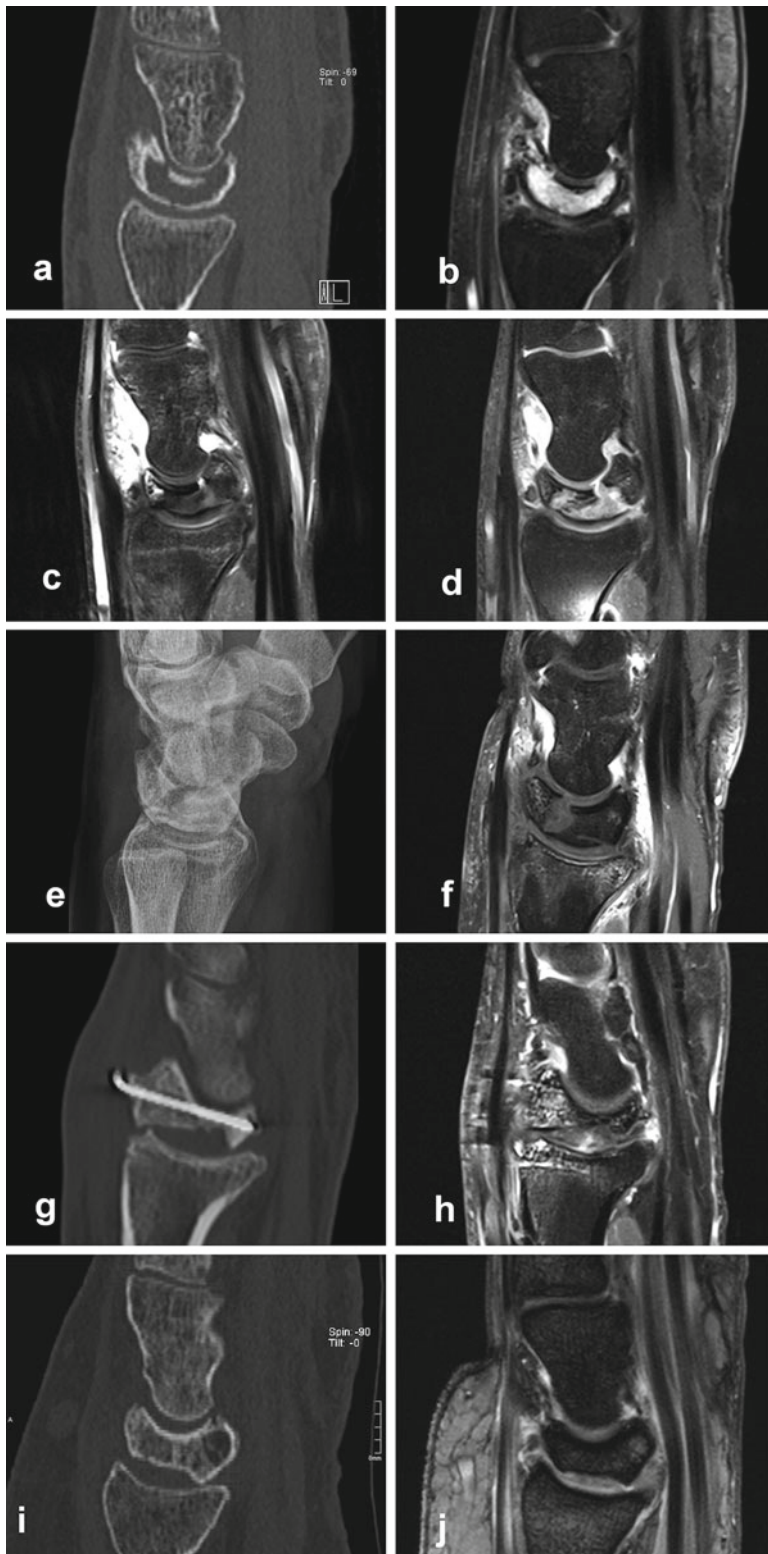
Collection of five different appearances of Kienböck's disease (all in stages IIIa or IIIb). (a, b) Hypervascularized repair zone (MRI pattern A). Sagittal CT and MRI (T1-w FSE fat-saturated after intravenous
